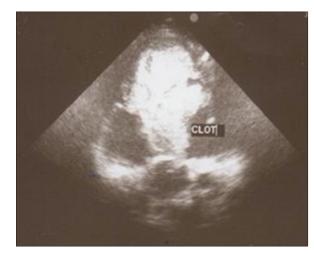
Echocardiography shows huge clot in left ventricle (surrounded by curve lines).
